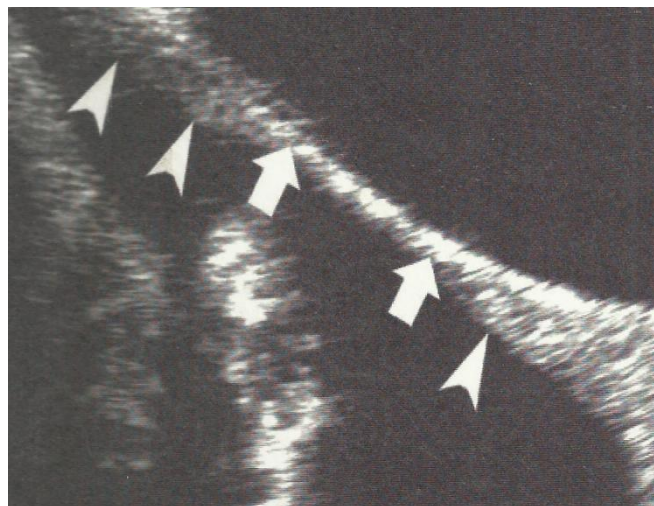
Longitudinal Sonogram showing uterine defect (between Arrows). The myometrical layer is clearly shown adjacent to the defect ballooning (Arrow heads)
